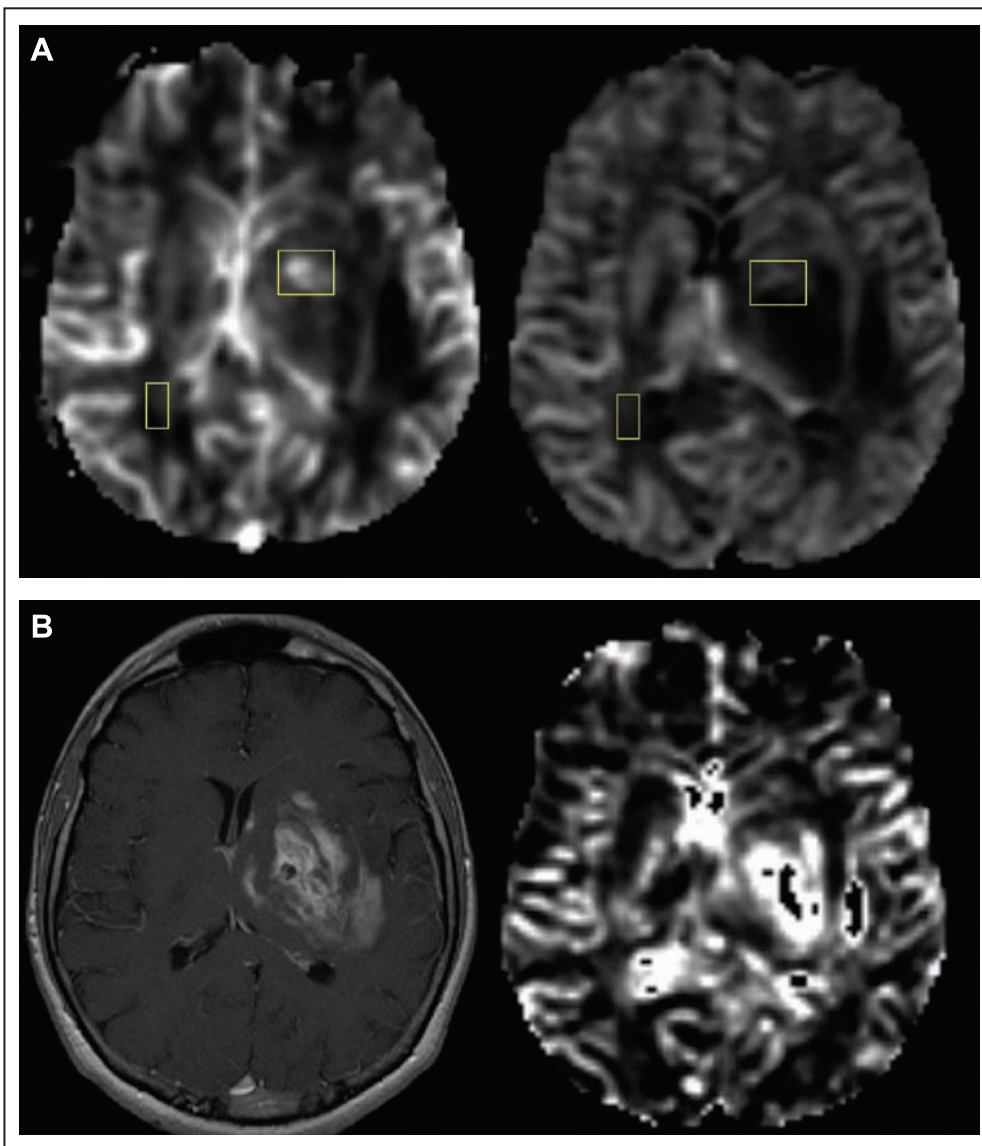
(A, B) Dynamic susceptibility contrast (DSC) of a patient with pilocytic astrocytoma. (A) Gradient echo-planar-imaging (EPI)-based cerebral blood volume (CBV) map; (B) spin echo EPI-based CBV map; (C) postcontrast T1-weighted image; (D) average vessel sizes based on the simultaneously acquired GE and SE EPI DSC data. Figure 2 courtesy of Melina Pescitides, MGH-HST A.A. Martinos Center for Biomedical Imaging, Boston, MA.
